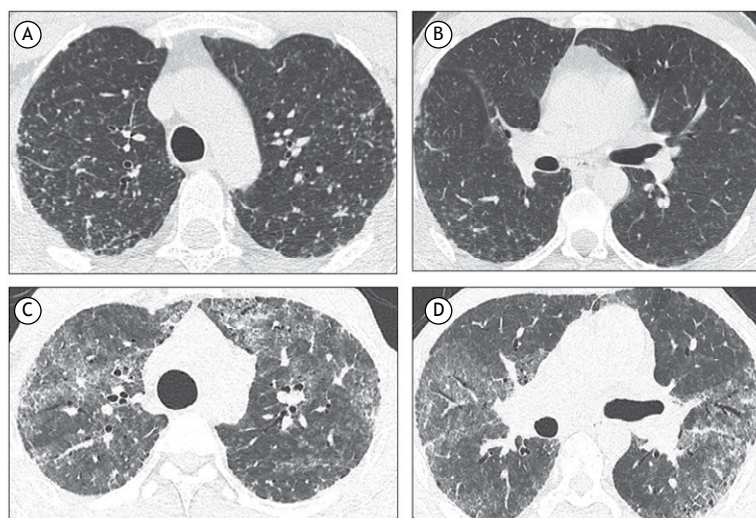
HRCT scans. Case 3 (Figures A and B): micronodular opacities distributed in a perilymphatic pattern, predominantly in the middle and upper lung fields. Case 4 (Figures C and D): ground-glass opacities and foci of parenchymal consolidation, predominantly in the middle and upper lung fields, as well as mild peripheral reticulation with traction bronchiectasis and bronchiolectasis.
